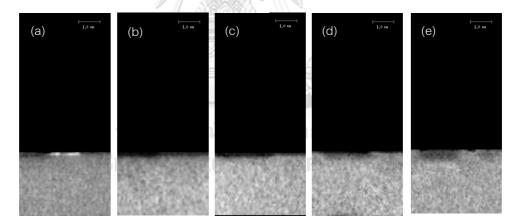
Typical micro-computed tomography images of cross-section of artificial root dentin caries
